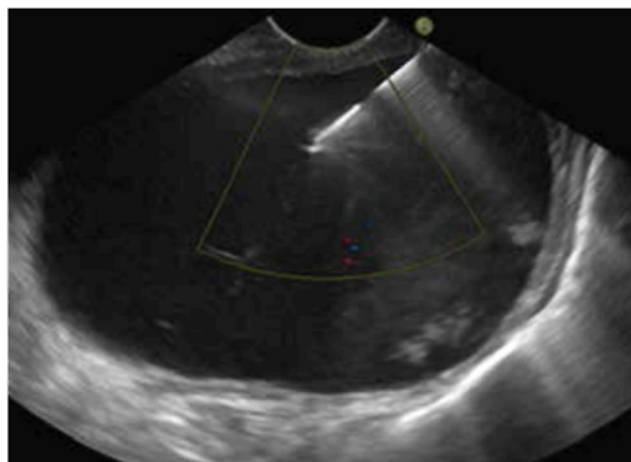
Endoscopic ultrasound fine needle aspiration of pseudocyst in the body of the pancreas
